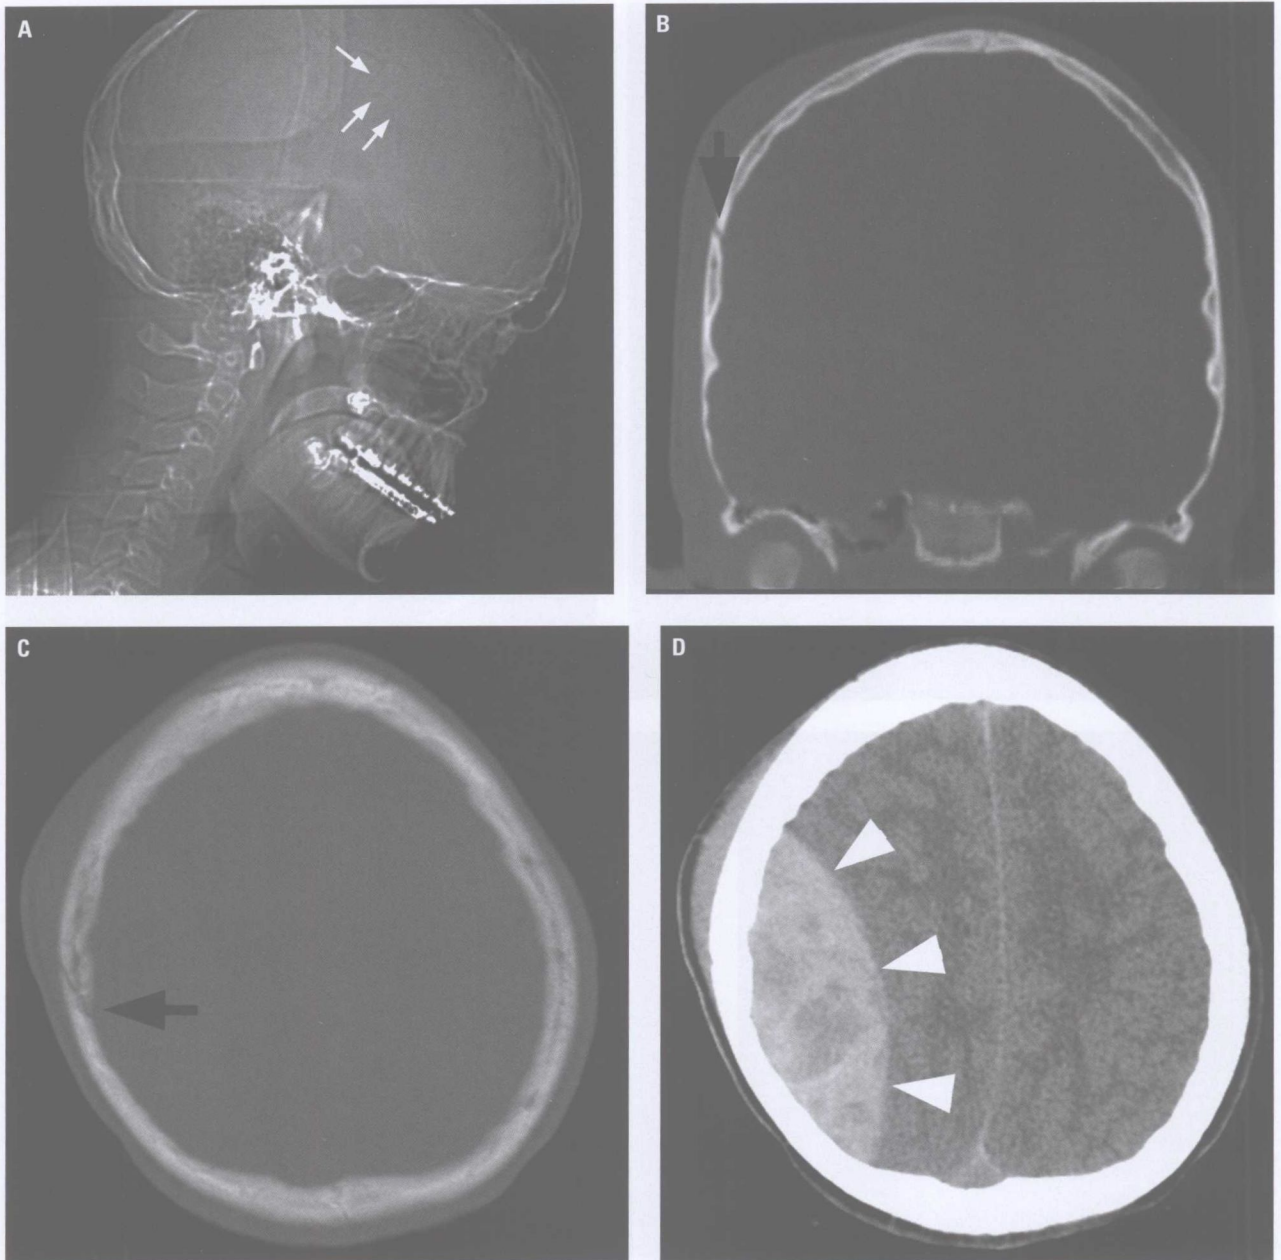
Lateral scout from CT of the head (A) of a 15-year-old skateboarder after a fall shows a lucent jagged line (*small white arrows*) suggestive of fracture. Coronal (B) and axial (C) CT images confirm a linear right parietal skull fracture (*black arrow*). Brain window of the same CT (D) shows a large heterogeneous epidural hematoma (*arrow heads*), which required surgical evacuation.
